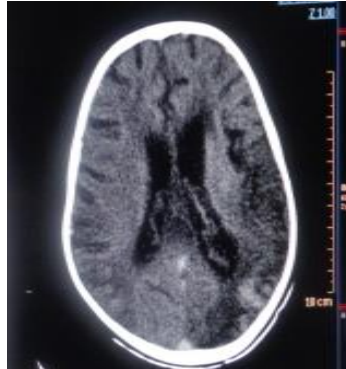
Axial non-contrasted helical brain CT scan showing the extension of the lesion into the occipital lobe
